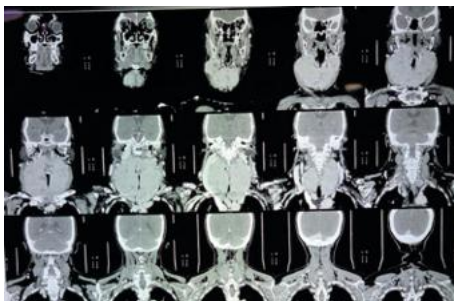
CT Neck Showing Severe Tracheal Compression and Retrosternal Extension.
